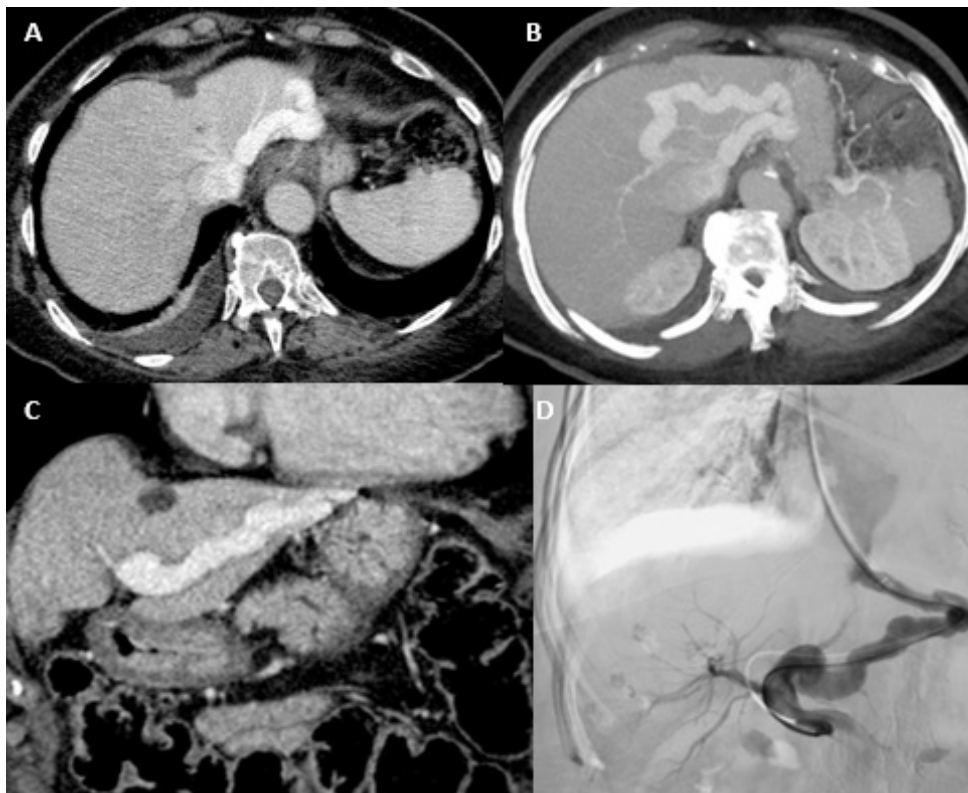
A - Axial soft tissue window, 3 mm slice thickness, contrast-enhanced CT; B - Axial soft tissue window, MIP reformation = 15 mm slice thickness, contrast-enhanced CT; C - Coronal soft tissue window, 3 mm slice thickness, contrast-enhanced CT; D - Abdominal venography.
